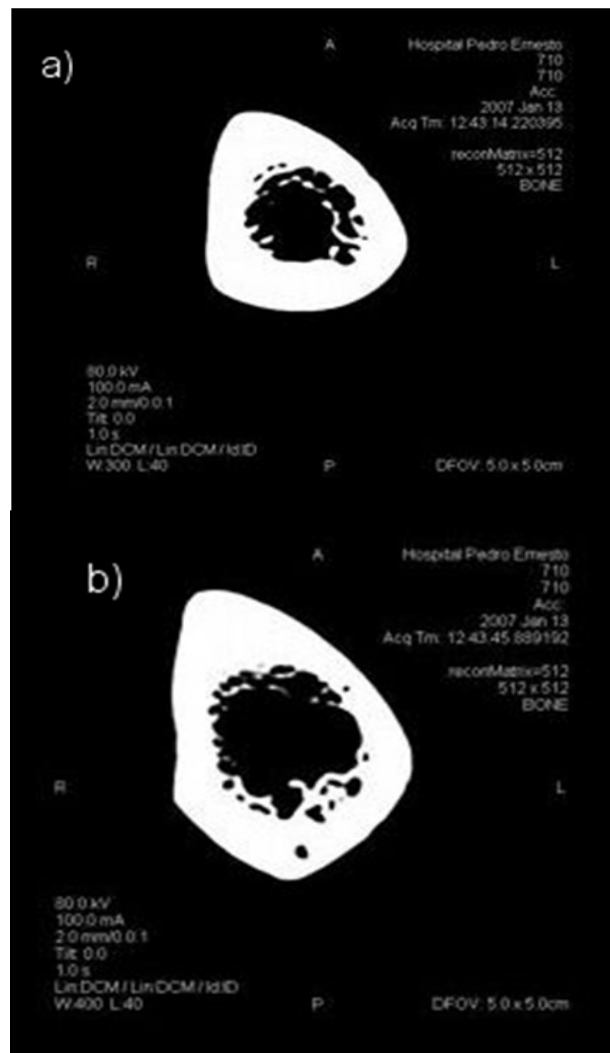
CT images of 35% (a) and 65% (b) cross-sectional tibia of individual 710.
